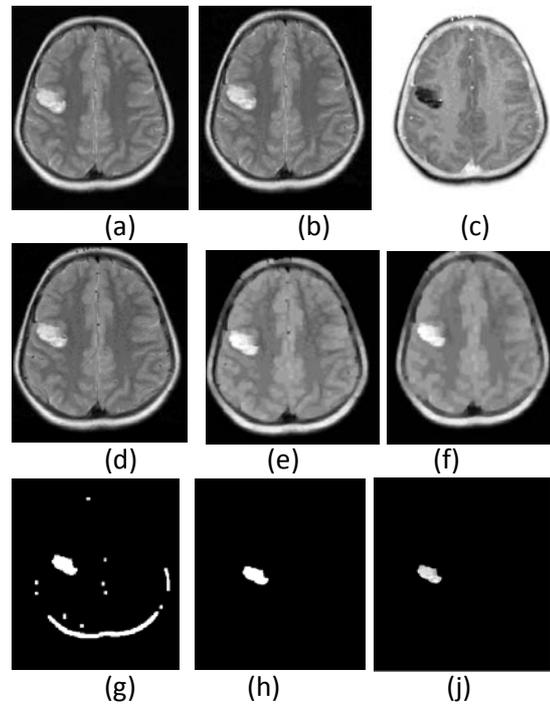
Extraction technique for high grade tumor from T2 weighted MRI slice
